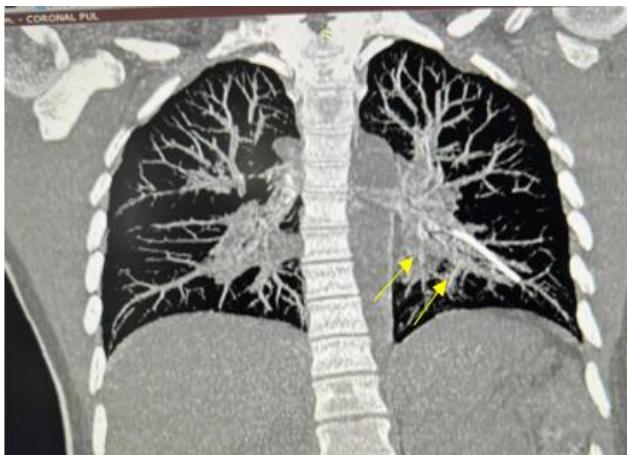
CT chest showing migrated implant into the left pulmonary artery branch (arrows).
